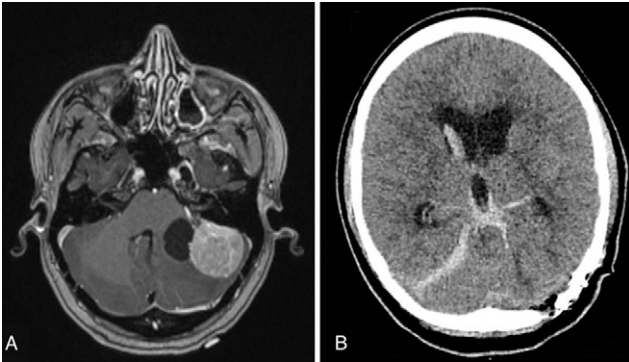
A: Preoperative magnetic resonance axial section demonstrating tumor enhancement adjacent to a well-circumscribed void region. B: Immediate postoperative computed tomography axial section demonstrating mFS 4 hemorrhage.
